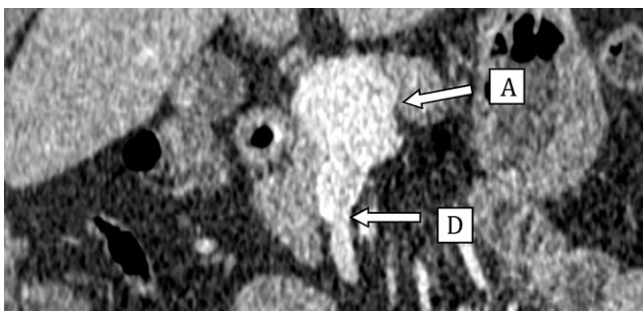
Coronal reformatted CT image shows portal vein aneurysm (A) at the confluence with SMV (D).
